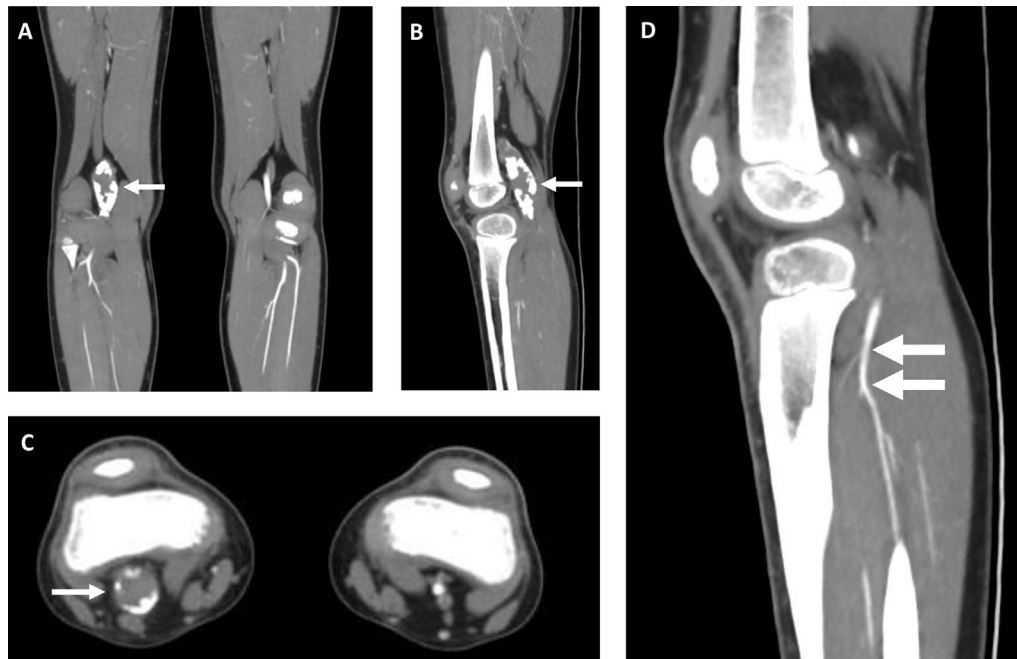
Computed tomography peripheral angiography. (A) Coronal view showing thrombosed, partially calcified right popliteal artery aneurysm (arrow). (B) Sagittal view. (C) Transverse view. (D) Sagittal section showing triple vessel runoff; upper arrow shows branching of anterior tibial artery and tibio-peroneal trunk, lower arrow shows branching of peroneal and posterior tibial arteries.
